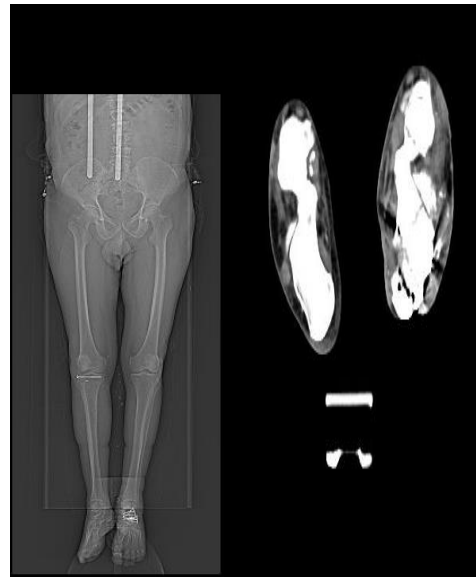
Lower extremity CT topogram (left) and lower extremity angio-CT (right) images of the patient taken in 2022
